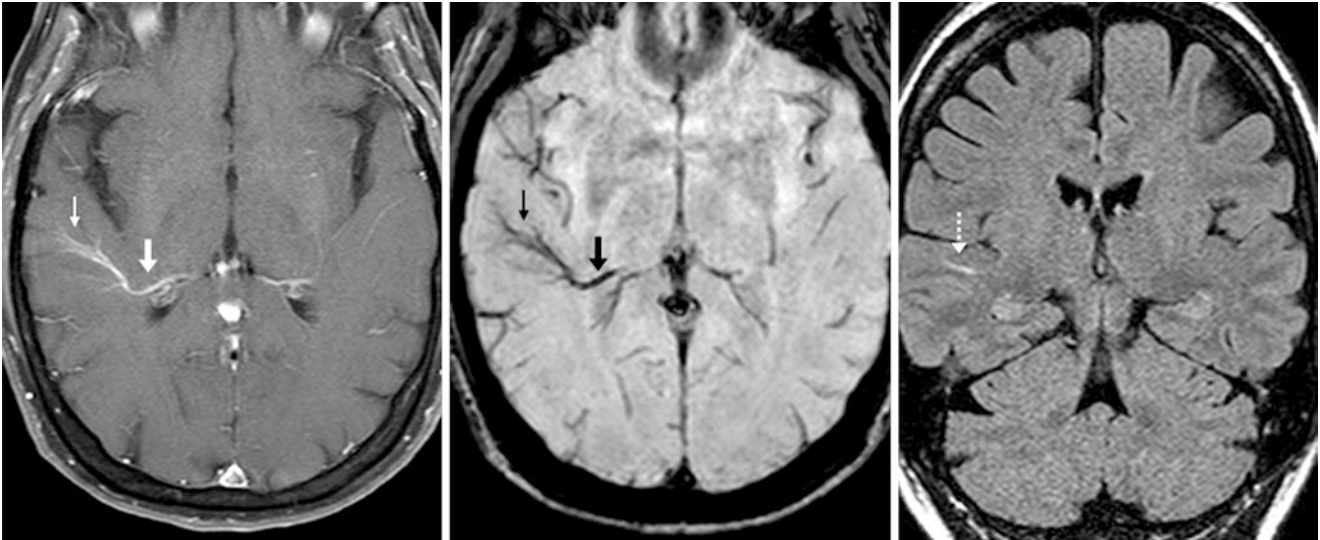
A 37 year old with headaches had a 1.5T MRI with axial postcontrast T1WI (*left*) and SWI (*middle*) that depicted a mildly prominent right temporal draining vein (*arrows*) from a DVA, fed by caput vessels (*thin arrows*). On FLAIR (*right*), there was faint hyperintense signal, which can be seen in some DVAs. DWI was normal (*not shown*)
